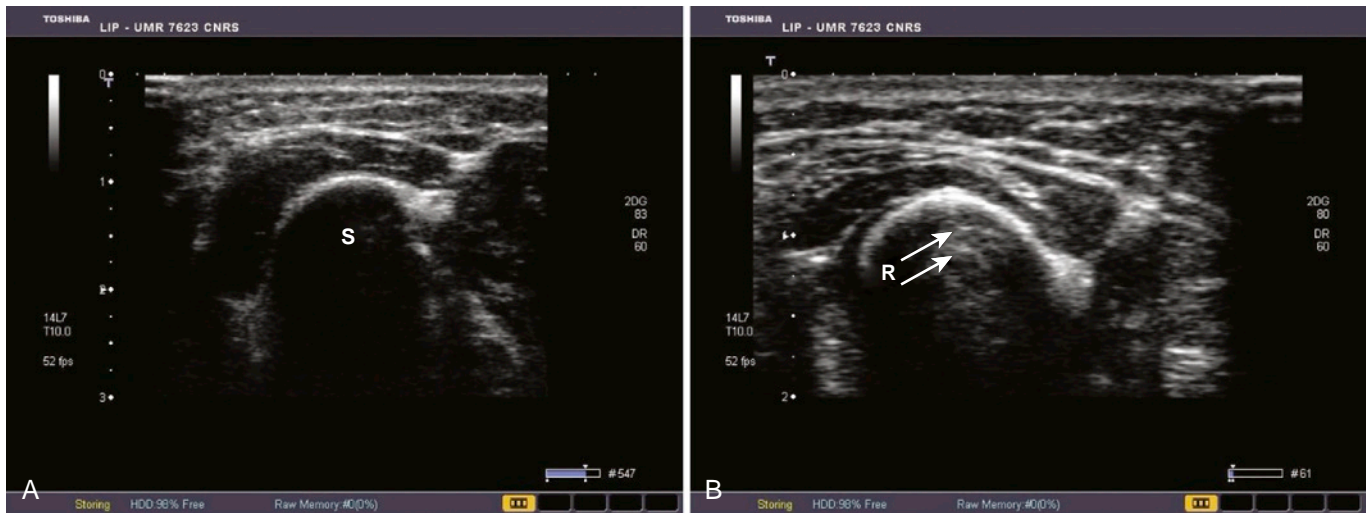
ARTIFACTS FROM STRONG REFLECTORS. Dorsal forearm views include a short-axis cross section of the radial bone. A, When ultrasound is strongly reflected at the tissue-to-bone interface, much less intensity is transmitted to deeper regions. This is called *acoustic shadowing* (S). B, Very strong echoes from the bone surface can reverberate (R) between tissue interfaces (arrows) or between the transducer face and the strong reflector. This produces a bright echo trail posterior to the tissue-bone interface. The echoes occur at regularly spaced intervals related to the distance between the reflective interfaces that give rise to the reverberations.
